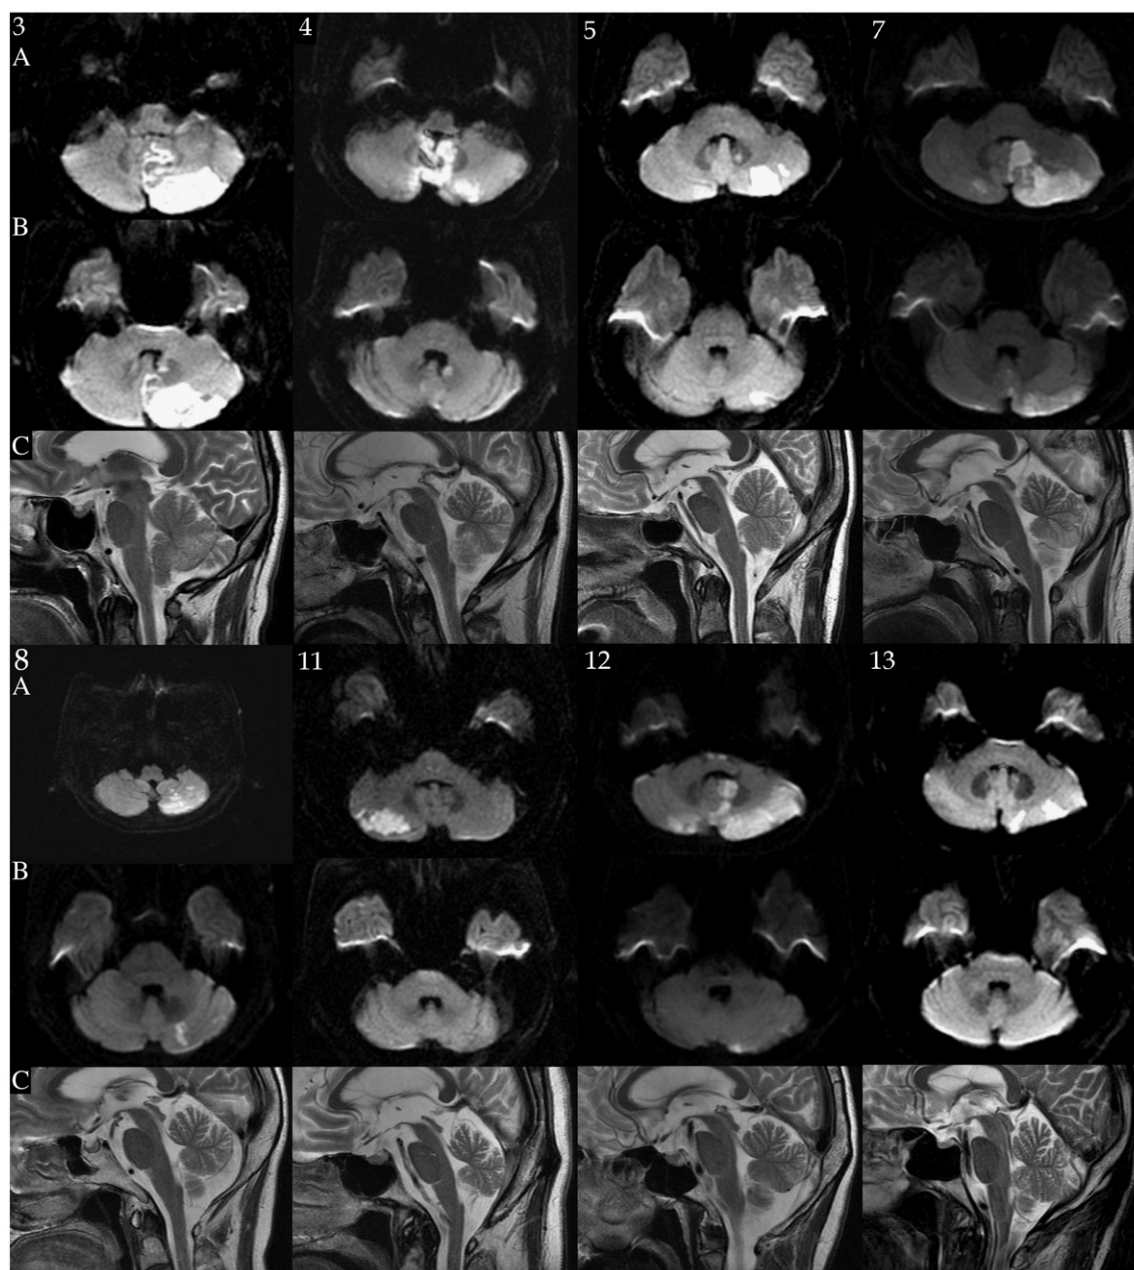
MRI findings in patients with ipsilesional SVV tilt without concomitant OT or skew deviation. Axial diffusion-weighted (A) MRI of the brain showed acute infarcts in the caudal cerebellum in the territory of the PICA. Axial diffusion-weighted brain MRI image (B) at the level of mid-pontine section, and mid-sagittal T2-weighted brain MRI images (C) showed that the nodulus was spared. The numbers on the figure correspond with the patients numbers assigned in Table 1. SVV: subjective visual vertical, OT: ocular torsion.
